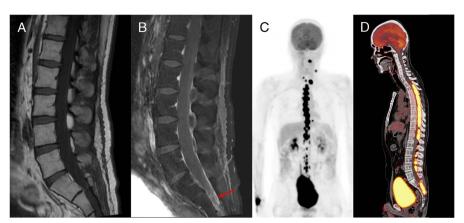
Sagittal T1 (A) and postcontrast T1 fat-saturated (B) MR of the lumbar spine demonstrate an enhancing lesion in the spinal canal at the level of the sacrum (arrow). MIP image of PET/CT (C) and sagittal fused PET/CT (D) demonstrate diffuse FDG-avid spinal leptomeningeal metastasis with SUV_{max} of 32. The findings are easily discernible on PET/CT. ^{1–8} Also noted are FDG-avid left cervical and supraclavicular nodal metastasis on MIP image. Traditionally, CSF cytology and MRI have been used in the diagnosis of leptomeningeal metastasis. ^{9–11} PET/CT has shown utility in this case by accentuating the extent of disease.
